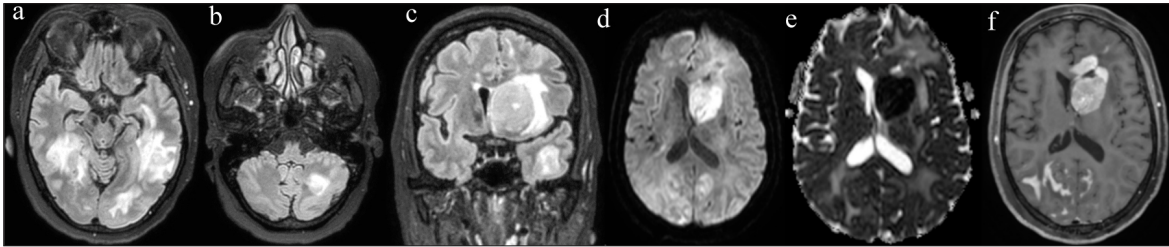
Brain MRI at the relapse (a-c: axial and coronal T2-weighted-fluid-attenuated inversion recovery (FLAIR) images; d-e: diffusion-weighted image and ADC map; f: axial post-contrast T1-weighted image) revealing new multiple lesions affecting the supra- and infratentorial cerebral parenchyma (a-c), the largest centered in the left anterior striatum-capsular region (c), with regular margins and diffuse/compact contrast enhancement (f), as well as marked restricted diffusion (d-e).
